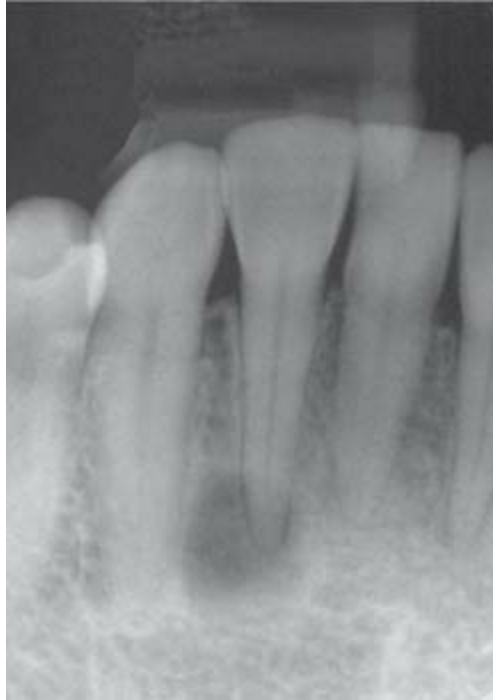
Radiograph showing what appears to be a mandibular lateral incisor associated with periapical lesion of a nonvital tooth. Although pulp necrosis can be suspected, the tooth tested vital. In this case, the appearance of apical bone loss is secondary to a cementoma.
